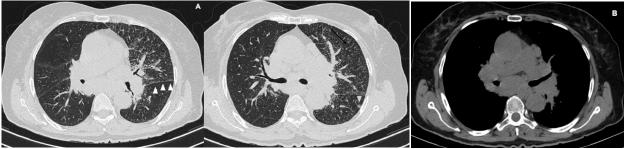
Lung sarcoidosis on HRCT
